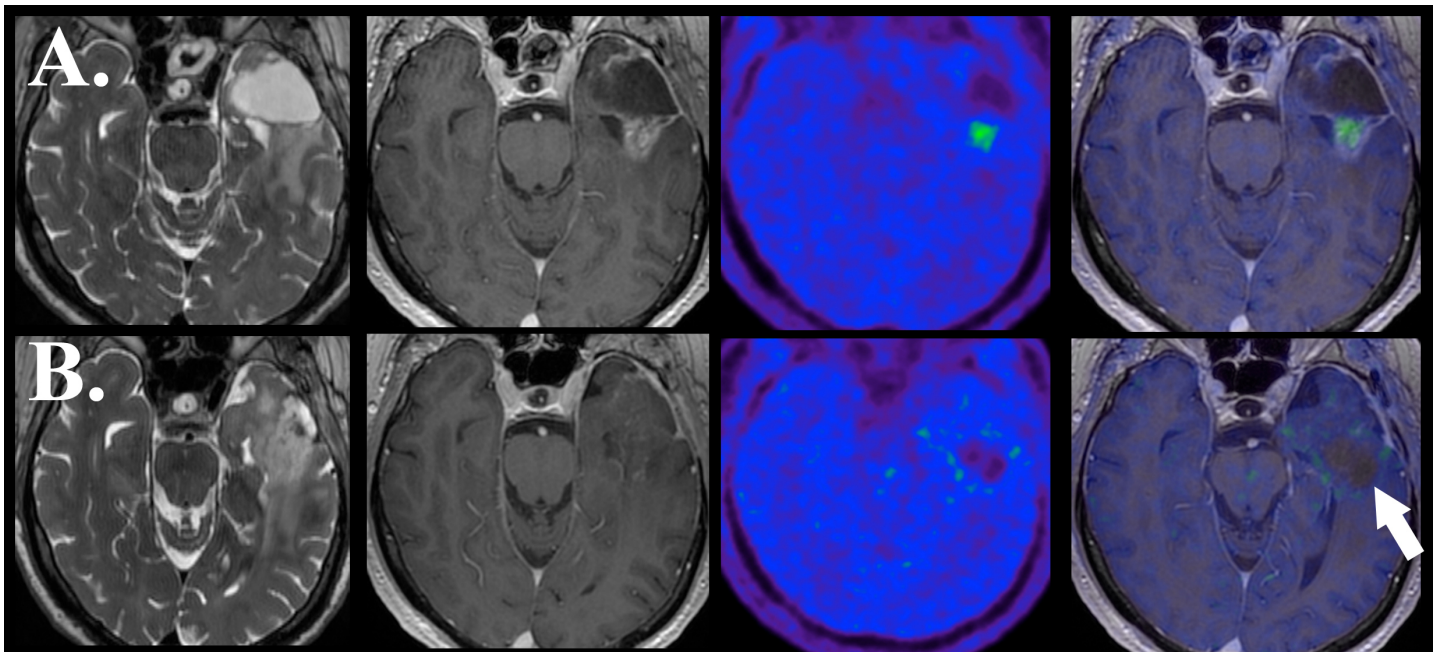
Single modality FMSIO PET/MR imaging of the brain in a patient with high grade glioma prior to (A) and 8 weeks following (B) bevacizumab therapy. Axial T2 (left), T1 post gad (center left), FMISO (center right), and fused FMISO T1 post gad (right) images demonstrate focal FMISO uptake within the contrast enhancing region on baseline imaging (Row A). Follow-up FMISO PET/MR examination demonstrates enlarged nonenhancing mass with reduced FMISO uptake compared to baseline imaging (Row B, arrow).
